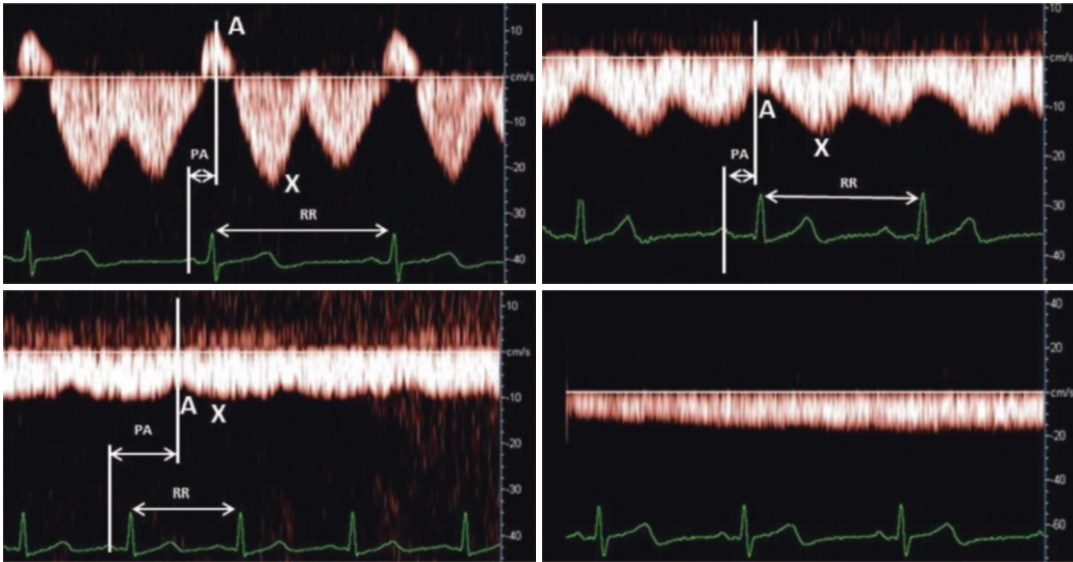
Identification of the different venous Doppler wave landmarks for measurement of venous Doppler flow impedance index and pulse transit time ratio
